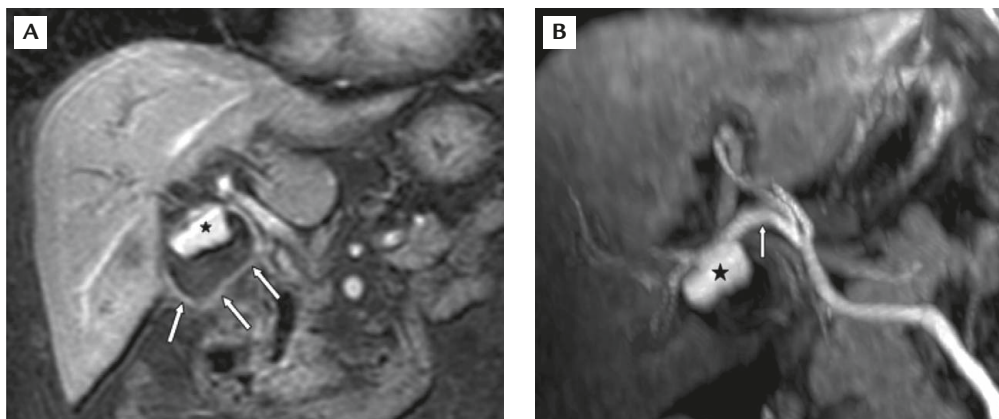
(A) Magnetic resonance imaging in the coronal plane and (B) maximum-intensity-projection reconstruction from the arterial phase of a dynamic contrast study performed with 3D fat-suppressed spoiled gradient echo sequence (TI: 14 ms; TR: 3.5 ms; TE: 0.9 ms) showed an engorged right hepatic artery (arrow in B) that supplied a dumbbell-shaped, wide-neck aneurysm (asterisk) in the gallbladder (arrows in A).
